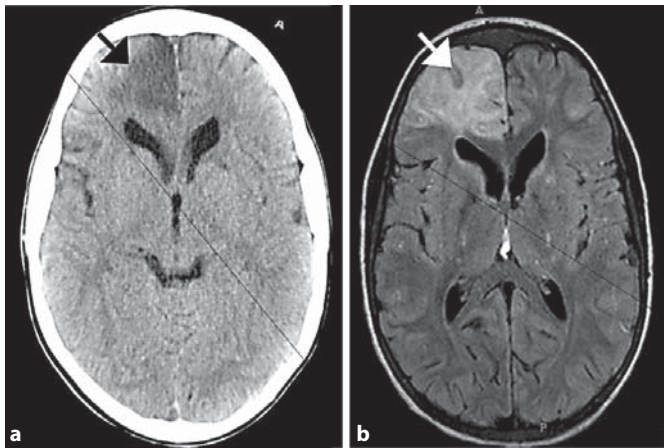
Neuroimaging of acute stroke in a 12-year-old HbSS patient who had plasma GFAP followed serially. a Noncontrast head CT immediately after clinical diagnosis of stroke showing a wedge of hypoattenuation in the right frontal lobe (arrow). b FLAIR MRI image 29 h after clinical diagnosis of stroke showing an evolving right anterior cerebral artery infarct (arrow).
